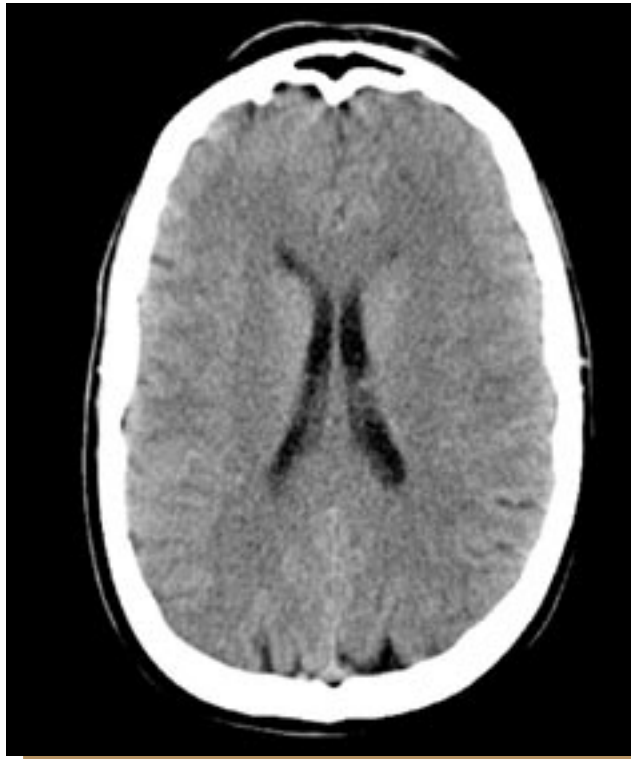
A noncontrast CT image of the brain through the level of the corona radiata is normal, with normal differentiation of the gray and white matter and no mass effect or intracranial hemorrhage.
